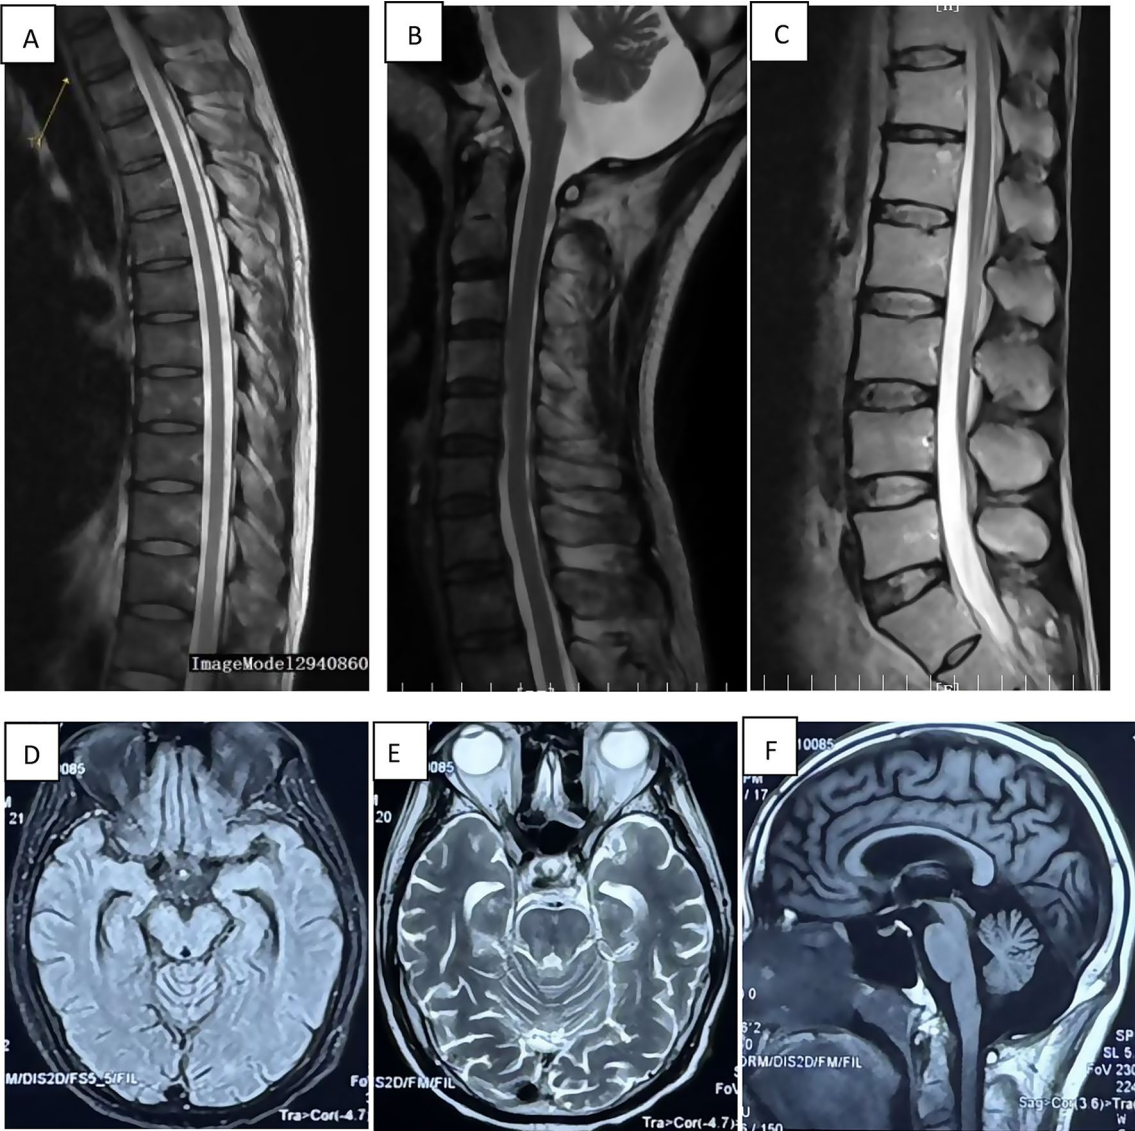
A: Thoracic spinal cord segmental MRI T2-weighted; B: cervical spinal cord segmental MRI T2-weighted; C: lumbar spinal cord segmental MRI T2-weighted; D: Axial T2 FLAIR; E: Axial T2-weighted; F: Sagittal T1-weighted
